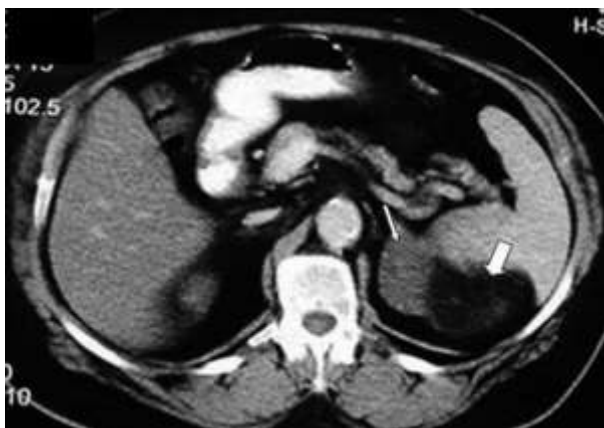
Enhanced abdominal CT scan revealed a left double adrenal mass: a myelolipoma (wide arrow) and an adrenal adenoma (thin arrow).
